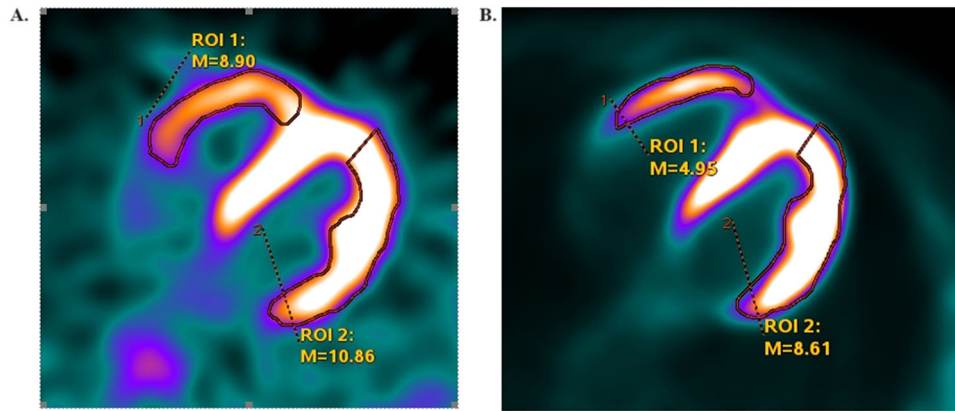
SUV calculation methodology for radiopharmaceuticals: (A) Transaxial positron emission tomography (PET) image with [13N]-ammonia. (B) Transaxial PET image with [18F]-fluorodeoxyglucose ([18F]-FDG). The regions of interest (ROI) are drawn on the free wall of the right ventricle and the lateral wall of the left ventricle.
